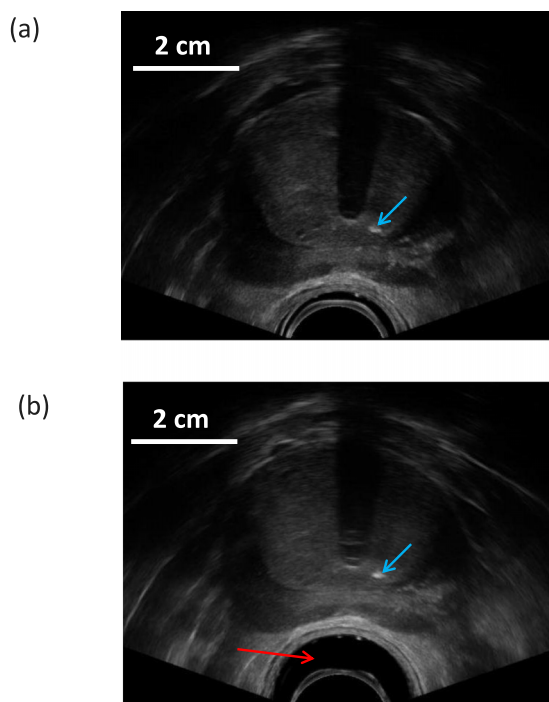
Prostate deformation resulting from the inflation of the ultrasound rectal probe cover during the seeds implant. (a) PreOp image when the cover is not inflated. (b) IntraOp image when the cover is inflated to elevate the prostate. Red arrow points to the inflated area by probe cover. Light blue arrows point to a calcification in both images. (See color online version.)
